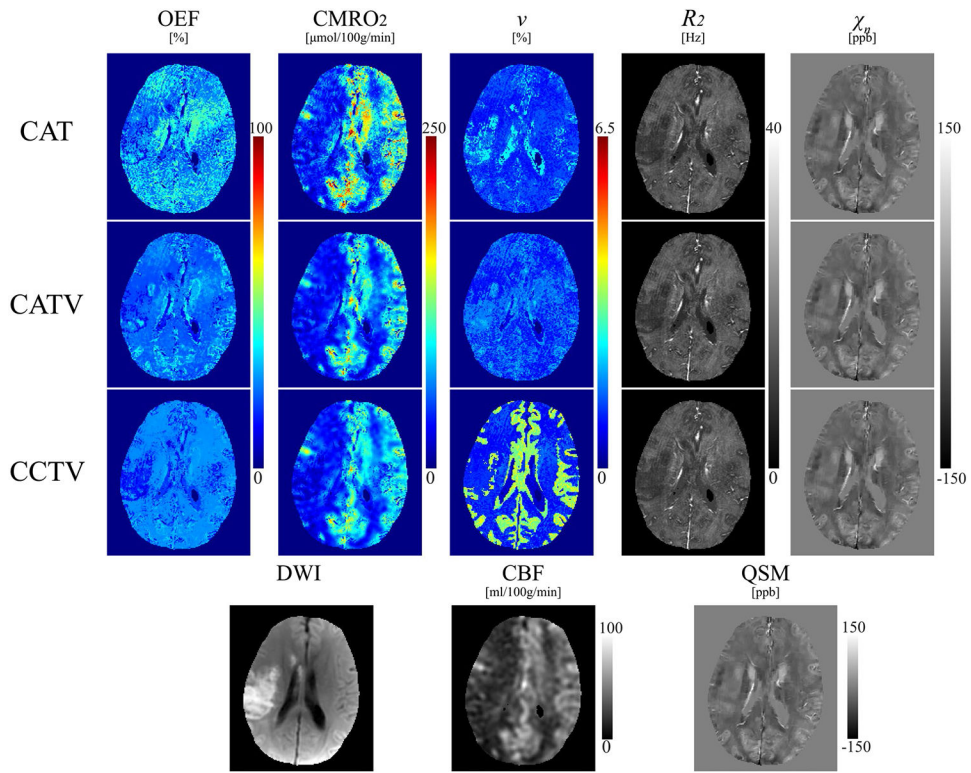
Comparison of OEF, $CMRO_2$, v , R_2 , and χ_n maps from QQ-CAT, QQ-CATV, and QQ-CCTV in a stroke subject (9 days following onset). The QQ-CCTV map shows a low OEF area that agrees better with the DWI-defined lesion than QQ-CAT and QQ-CATV
